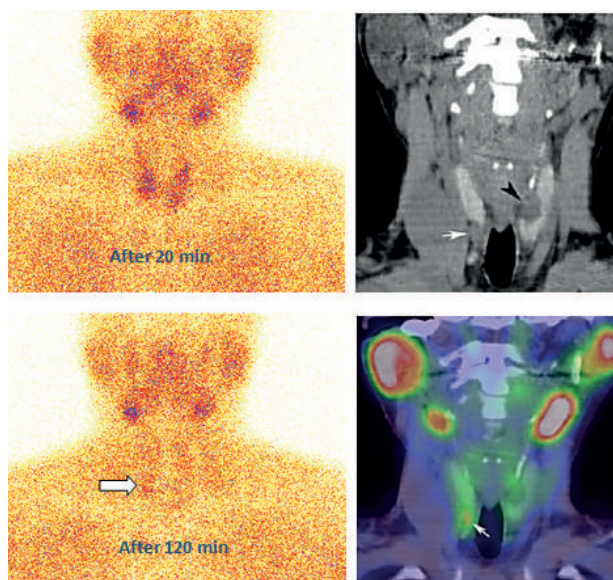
A. Initial and delayed phases of Tc99m-technetrite planar scintigraphy showed abnormal uptake. B. Coronal non-contrast enhanced CT of the neck. A lesion was detected in the inferior right portion of the thyroid lobe (arrow). A cystic mass was detected in the left lobe of the thyroid (arrowhead). C. A coronal fused image (SPECT/CT). The fusion image demonstrated a faint abnormal uptake of Tc99m-technetrite in the inferior right portion of the thyroid lobe (arrow). Right inferior hyperplastic parathyroid gland was removed during surgery.
